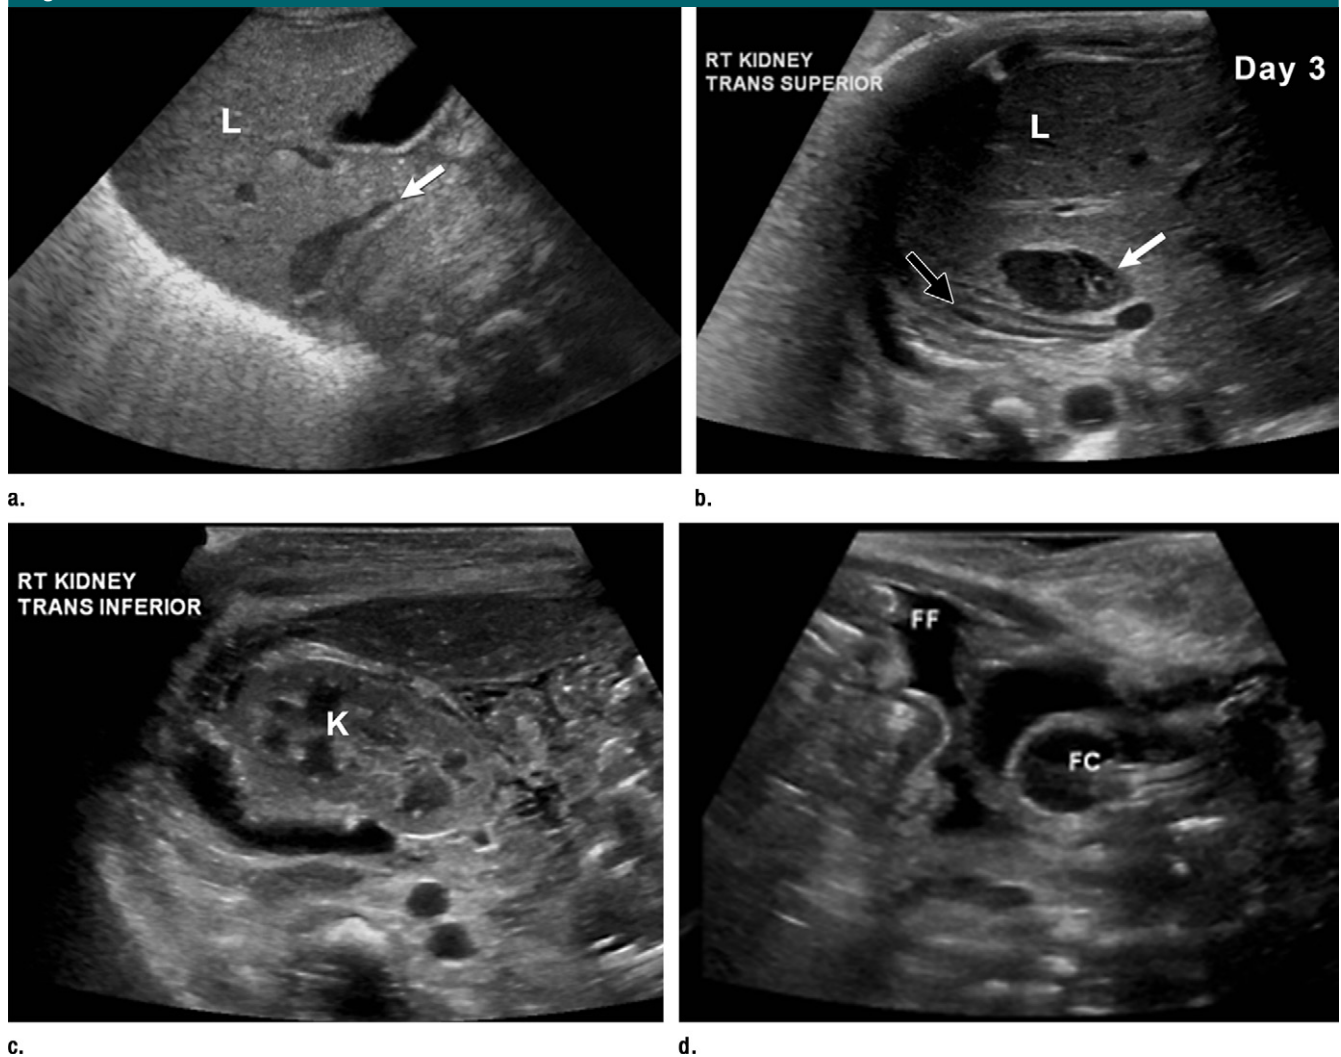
FAST in a newborn. Images obtained in the premature infant (born at 34 weeks gestation) from Figure 16. FAST was performed at the infant's bedside after delivery. (a) On day 1 there were multiple findings, including a small liver (*L*) laceration (arrow). (b) On day 3 the liver (*L*) laceration (white arrow) had increased in size (black arrow = adrenal gland). (c) Fluid was noted surrounding the right kidney (*K*). (d) Free fluid (*FF*) was also noted in the pelvis. No CT was performed, and the newborn was treated conservatively. *FC* = Foley catheter.
